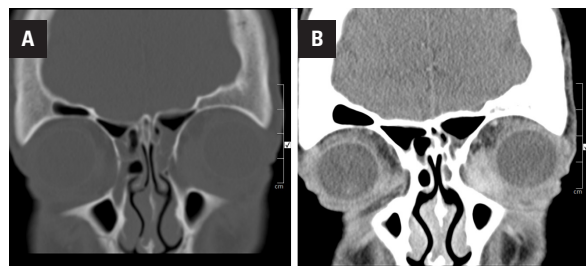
A. Orbit CT with contrast coronal views bone; B. Soft tissue (B) windows. A lobulated soft tissue mass (arrow) at left medial canthus, invading the left lacrimal sac (A) with focal destruction of the lacrimal bone (B)
